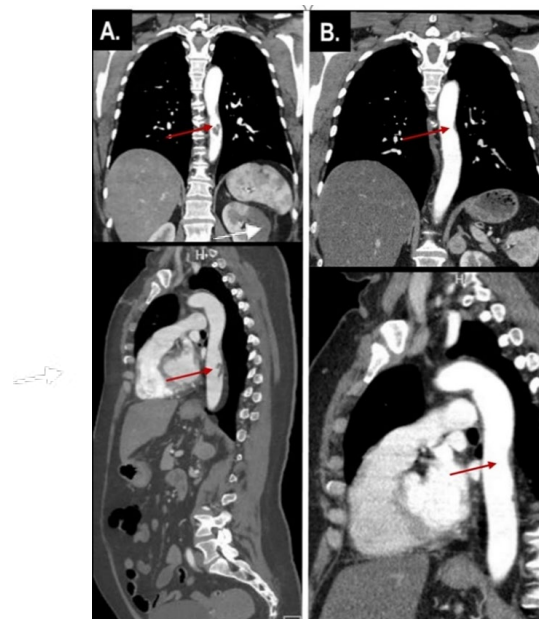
A) Admission CTA images show 8.3 x 2.7 cm left renal hypoattenuation consistent with infarction (white arrow). Normal caliber thoracic aorta with mural thickening in the mid thoracic aorta with associated mild atherosclerotic plaque and 10x6 mm posterior eccentric thrombus within caudal thoracic aorta (red arrow). Tiny right lower pole renal infarct. B) At three month follow-up: A significant improvement in irregular eccentric thrombus in the posterior descending thoracic aorta with nearly resolved endophytic portion extending into the aortic lumen.
